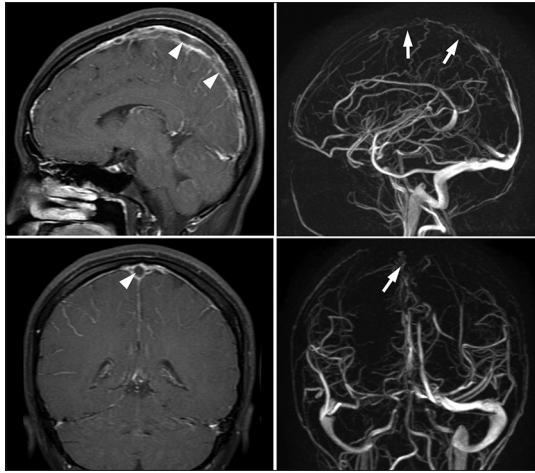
Magnetic resonance imaging T1-weighted fast spin echo with contrast showed high signal subacute clot in superior sagittal sinus (arrowheads in the left upper and lower figures). Magnetic resonance imaging venography showed decreased venous flow in superior sagittal sinus (arrows in right upper and lower figures)
